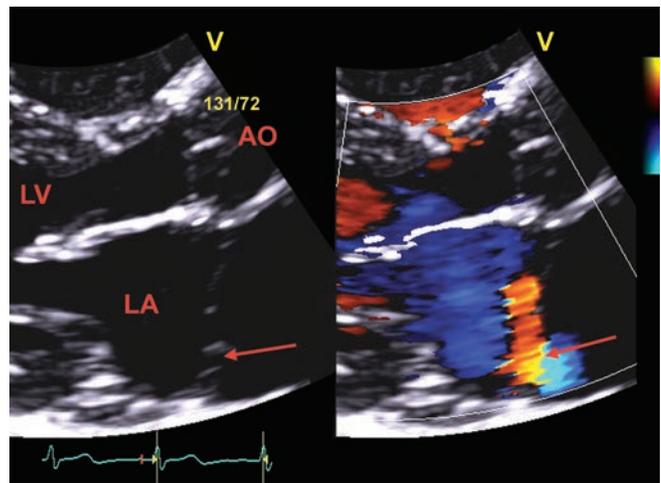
Parasternal long-axis view with color flow Doppler showing turbulence at the location of the membrane (arrow).
